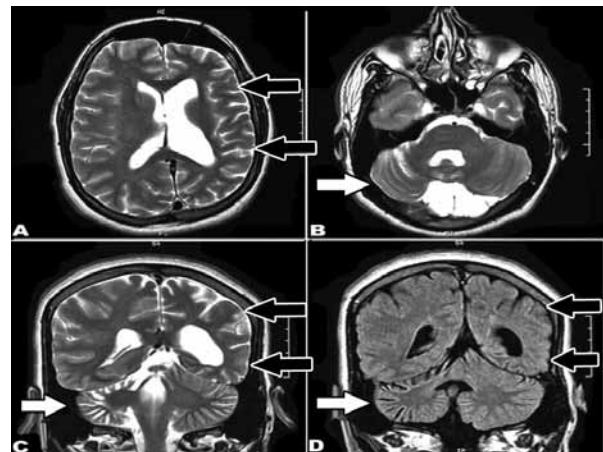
Patient MRI showing axial (A, B), coronal (C) T2 weight images and coronal FLAIR (D) showing moderate parenchymal and cortical atrophy involving the left cerebral hemisphere (black arrows) and the contralateral cerebellar hemisphere (white arrows). Note the prominence of the sulci and the ventricular dilatation.
